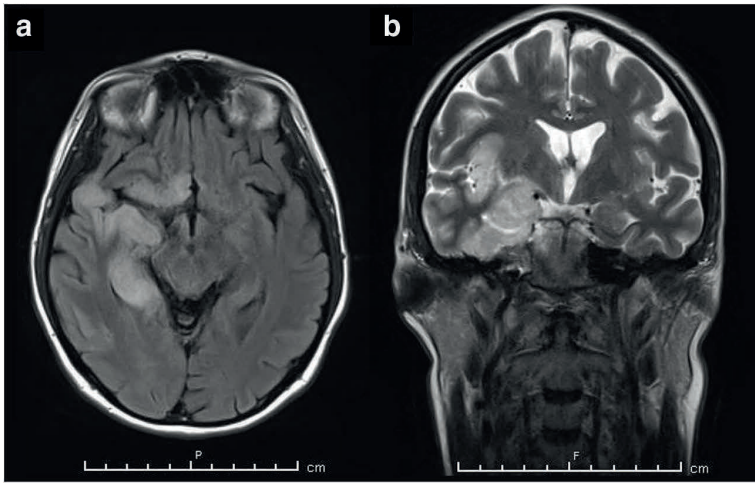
MRI in Herpes simplex encephalitis. (a) Axial projection with hyperintense lesions of insular, temporal, and frontal right lobes. (b) Coronal T2 projection with hyperintense lesions of temporal right lobe.
